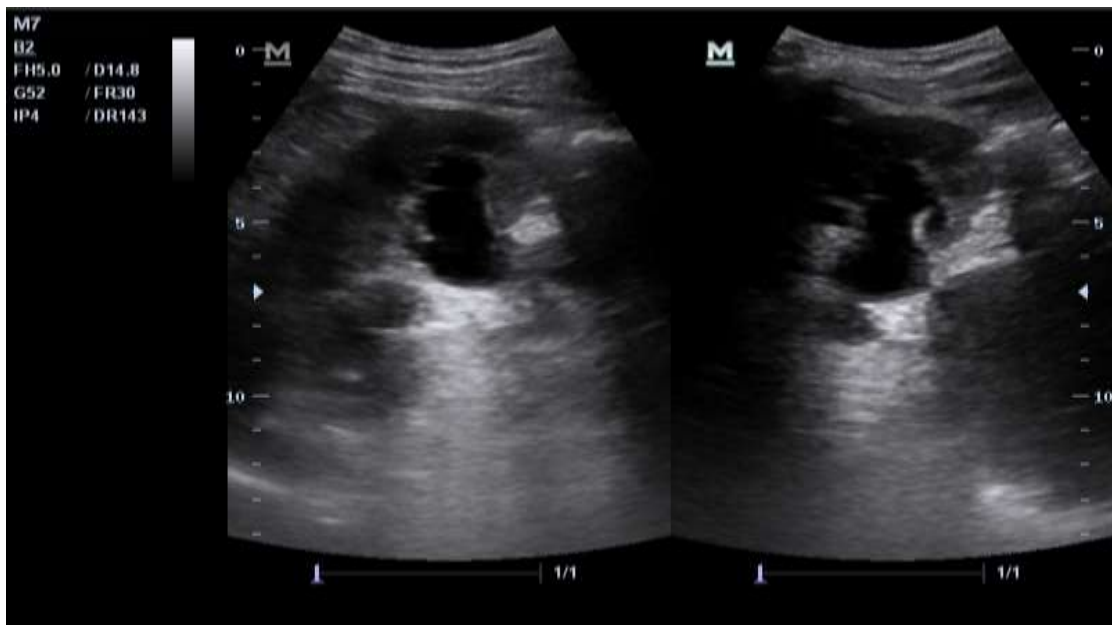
Longitudinal ultrasound images showing PCN placement using Single step technique in a 37 year old male with pelvic lymphoma and grade 3 hydronephrosis.
